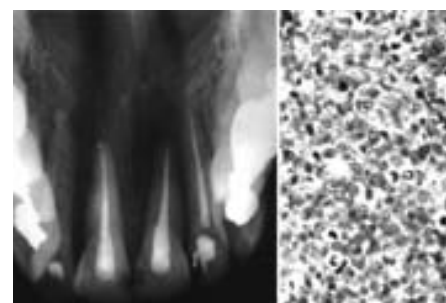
Poorly defined persistent periapical radiolucencies associate with apices of maxillary incisors. The biopsy (right) was diagnosed as lymphoma.
